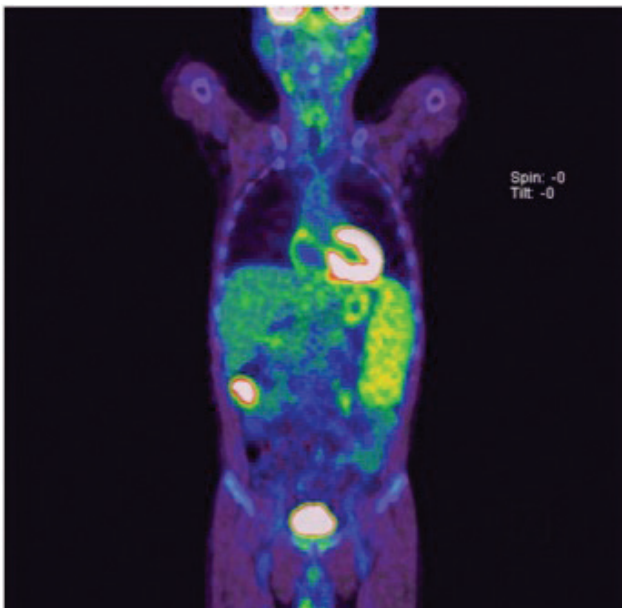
Whole-body positron emission tomography with fluorine-18 fluorodeoxyglucose (FDG). Intense FDG uptake in the ascending colon and mild focal metabolic activity in the left internal jugular region and diffuse increased FDG activity related to splenic lesions associated with splenomegaly.
